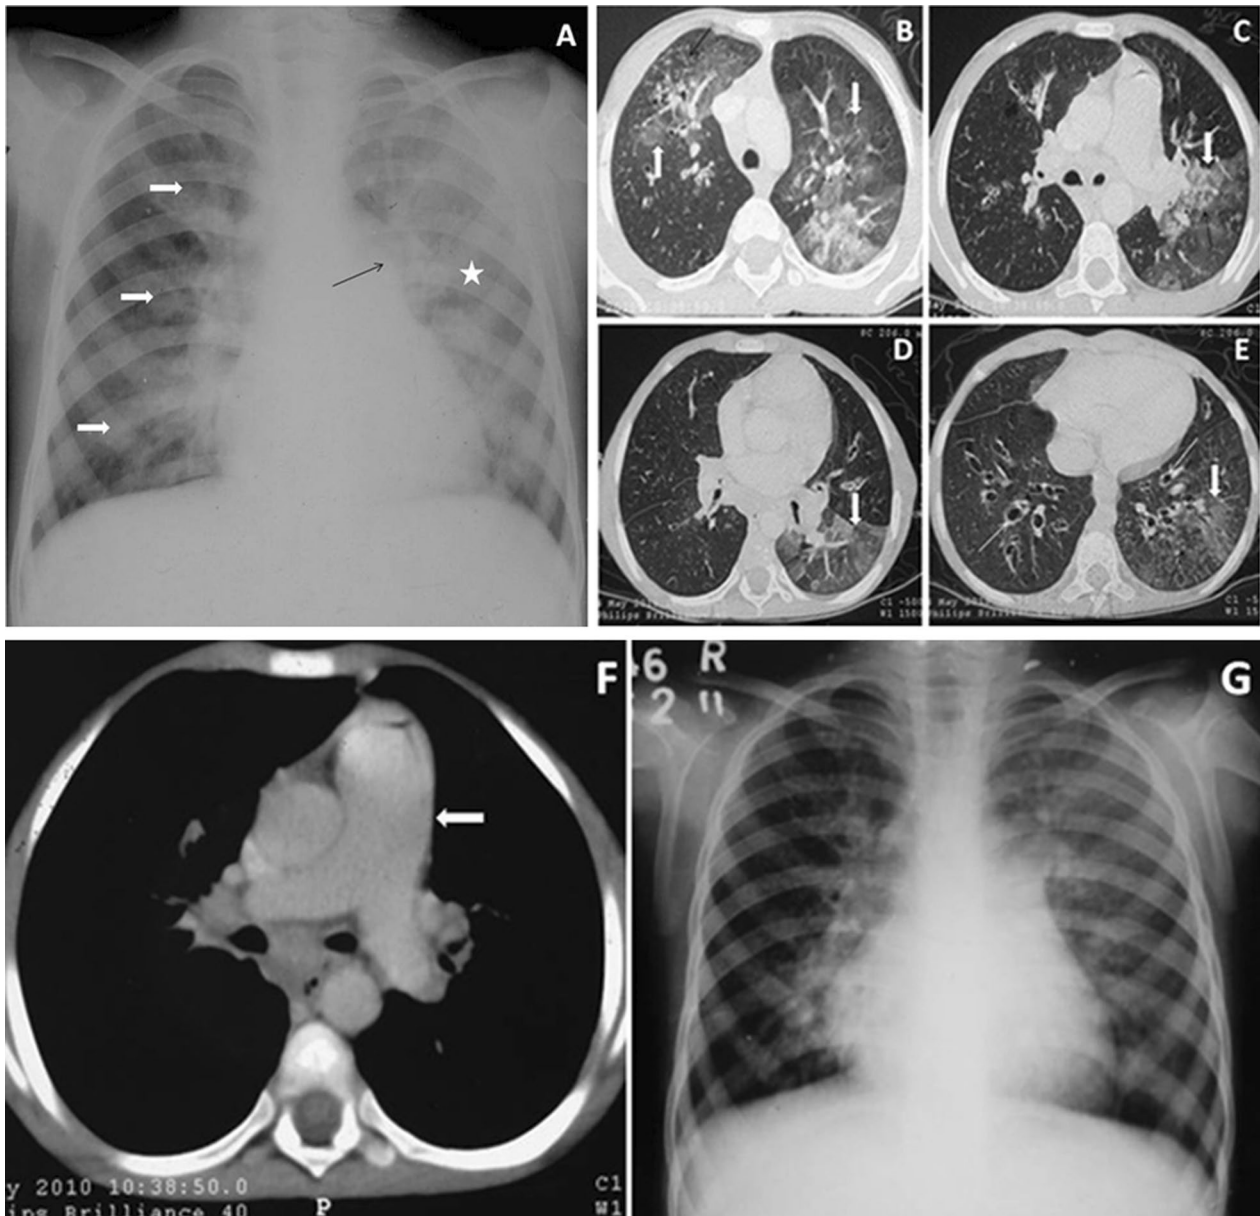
Fungal Infection. Frontal chest radiograph in a 13-year-old HIV-positive male child, presented with fever & cough for 4 days, shows diffuse haze/GGO involving left lung (asterisk, A), and patchy areas of inhomogenous opacity in right lung (white arrows, A). Pulmonary bay fullness with peripheral pruning of pulmonary arteries (suggesting pulmonary hypertension) is evident (black arrow, A). CT scan (axial, lung window) shows GGO involving anterior segment of RUL, apico-posterior segment of LUL and superior, anteromedial & lateral basal segments of LLL (thick white arrows in B,C,D,E). Ill-defined centrilobular nodules are also visible in similar anatomic locations (black arrows in B,C). GGO along with interlobular septal thickening in superior segment of LLL gave crazy paving appearance to the involved segment (thick white arrow, D). Bilateral cystic & traction bronchiectatic changes are also present (thin white arrows, E). Enlarged pulmonary artery suggestive of pulmonary hypertension (arrow, F) is evident on axial CECT chest (mediastinal window). CD4 count was 131 cells/cu.mm. BAL/sputum did not isolate any microorganism. Patient was clinically sick and hypoxic. On the basis of clinical and radiological findings, a probable diagnosis of *Pneumocystis jiroveci* pneumonia was made. Patient was treated with trimethoprim/sulfamethoxazole combination and improved clinically as well as radiologically (G)
